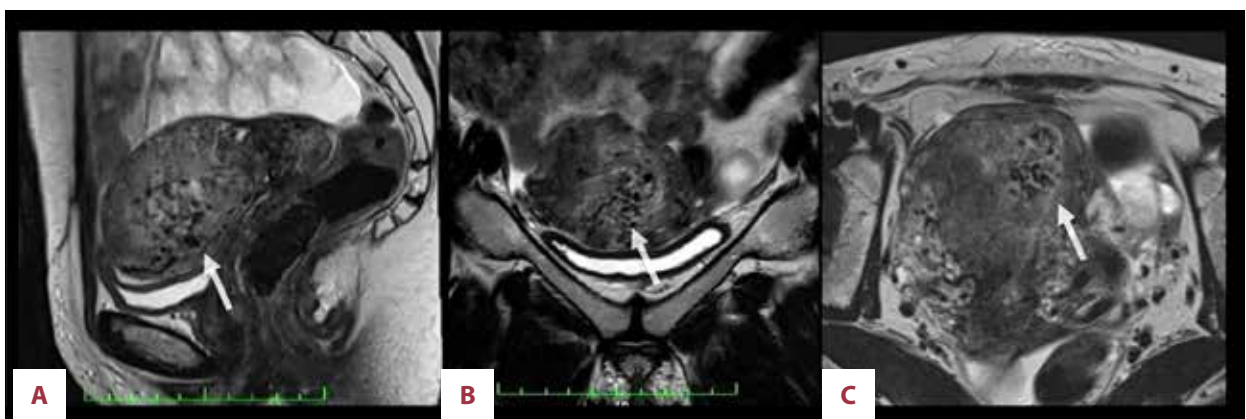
Pelvic MRI: sagittal (A), axial (B), and coronal (C). T2-weighted TSE sequences: ill-defined mass (arrow) of multiple vascular-like serpiginous structures with flow void involving the whole myometrial anterior wall of the uterus. MRI – magnetic resonance imaging; TSE – turbo spin-echo.
